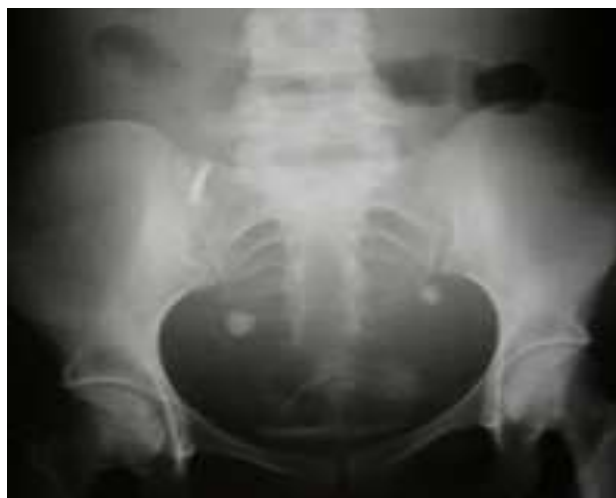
Plain pelvic X-ray film of a 23 year old female with anuria. Secondary bilateral ureteric calculi due to total distal ureteric obstruction confirmed at cystoscopy.
